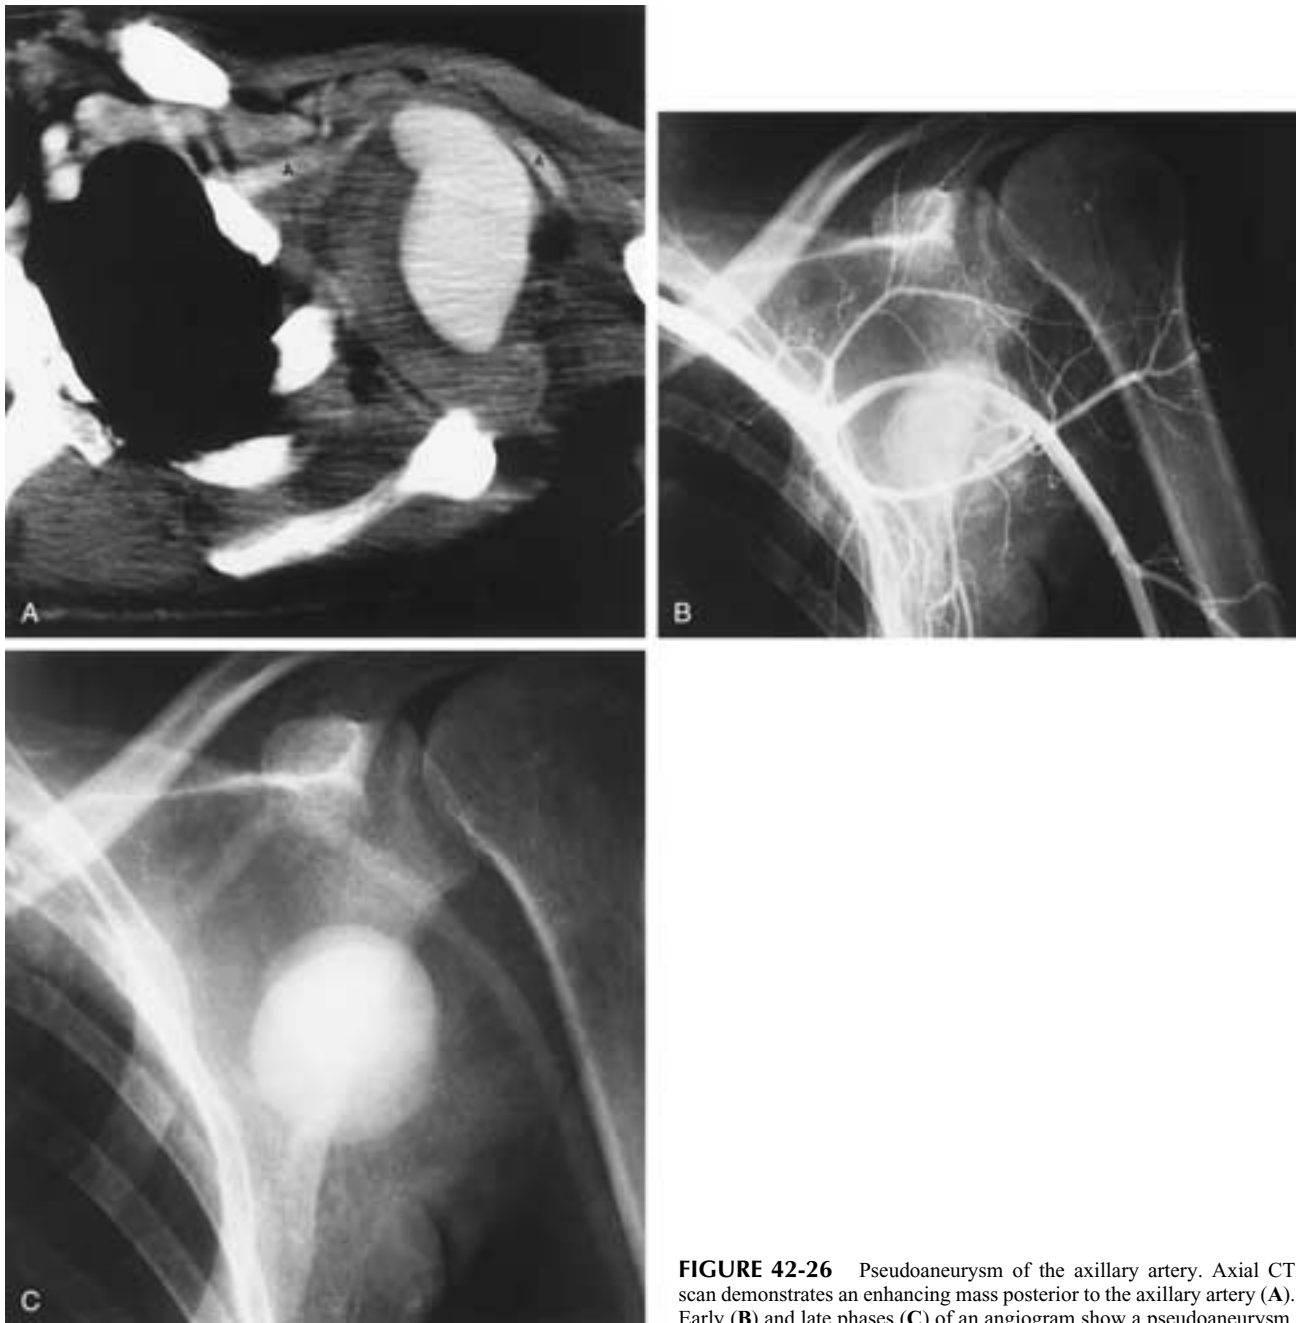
Pseudoaneurysm of the axillary artery. Axial CT scan demonstrates an enhancing mass posterior to the axillary artery (A). Early (B) and late phases (C) of an angiogram show a pseudoaneurysm.
